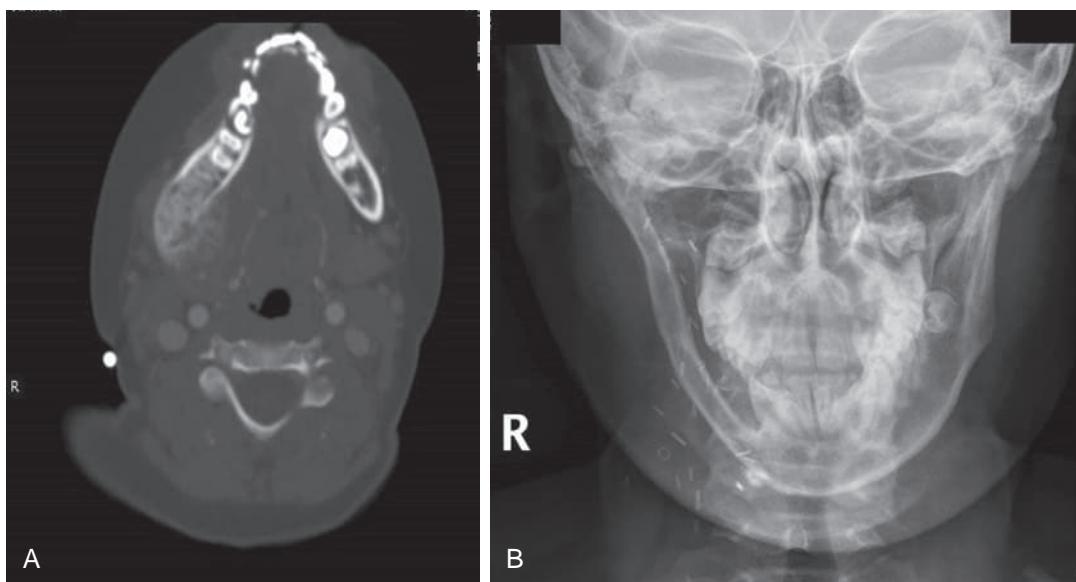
Late effects of surgery. (A) Computed tomography image showing tumor of the right mandible. (B) Radiograph of the same patient taken after tumor resection and mandible replacement with a resected rib. (Courtesy Dr. Terry Vik.)
